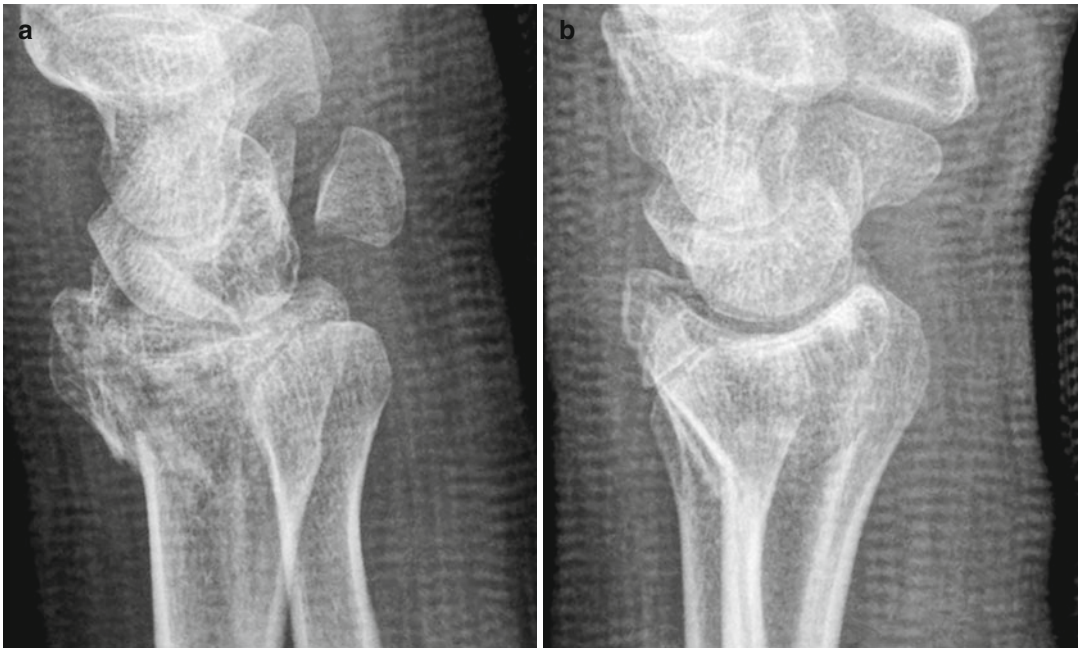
Standard and angled radiographs (a) Standard lateral (b) Angled lateral
